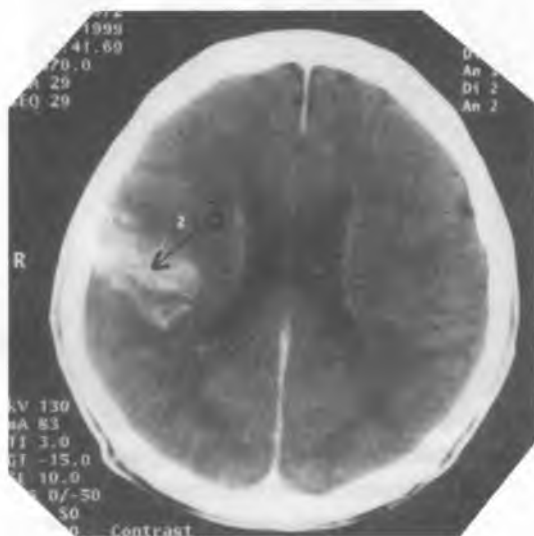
CT – after contrast administration – intensified structures of the angioma – nidus (3)
